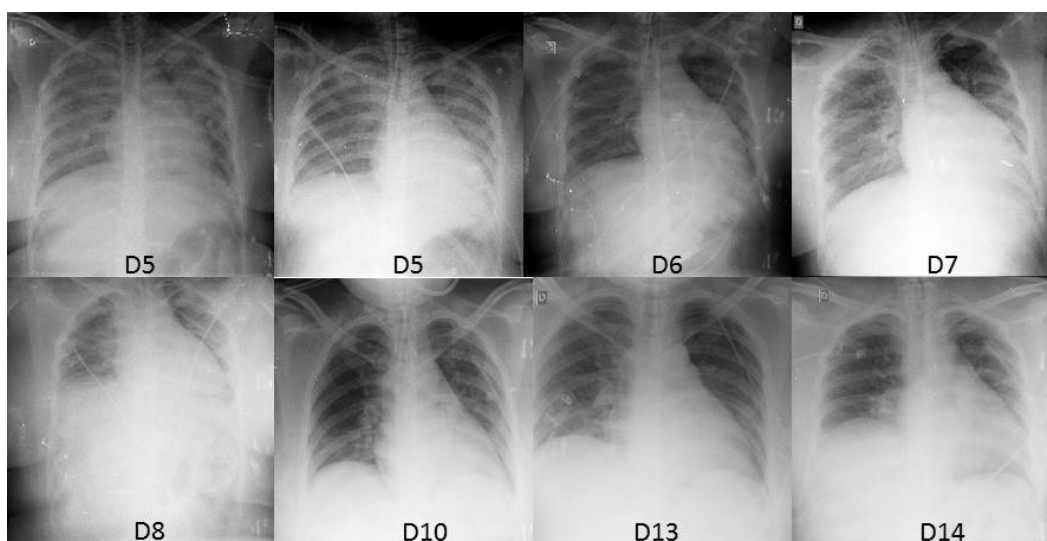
(Chest radiography). Evolution of pulmonary changes between D5 and D14, showing gradually progressive improvement with Intensive Care and clinical managements.
